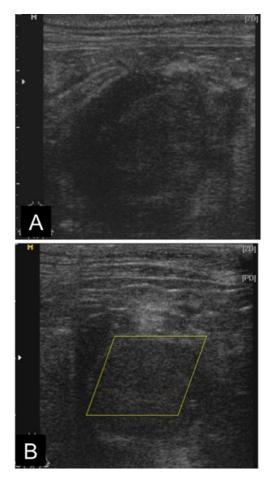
Ultrasonography of the Mass. (A) A hyperechoic omentum containing hypoechoic regions and a mass with a heterogenous echogenic pattern was observed. (B) Vascular response was not seen in the mass on the power Doppler mode.
